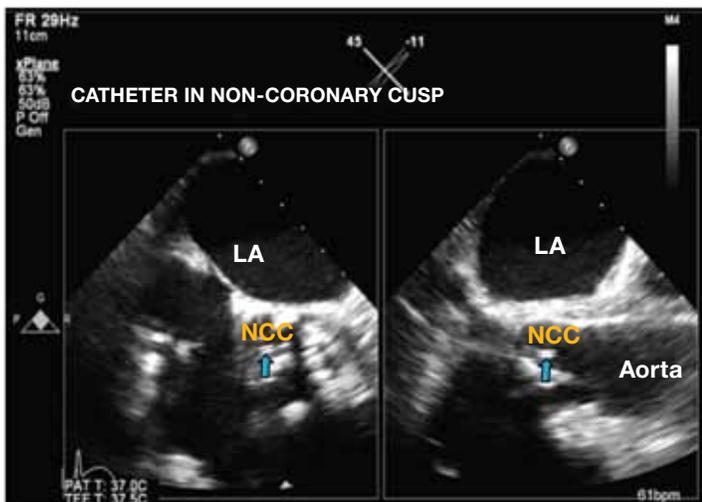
Transesophageal echocardiogram (TEE) can be used to assist with localization of catheters and devices. In this example, a pigtail catheter is clearly depicted (blue arrow) within the noncoronary cusp (NCC) of the aortic root. This form of biplane imaging can easily be created using the 3D matrix TEE probe.
